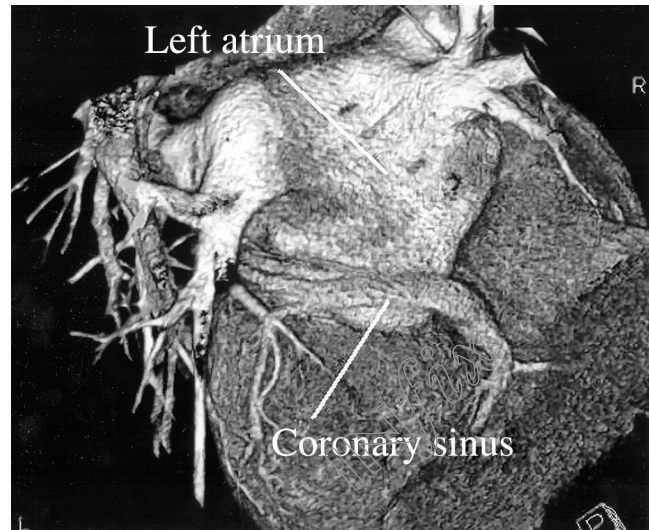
Three-dimensional reconstruction image of heart with 64-slice MDCT (multidetector computed tomography) six months after the closed biatrial procedure.
